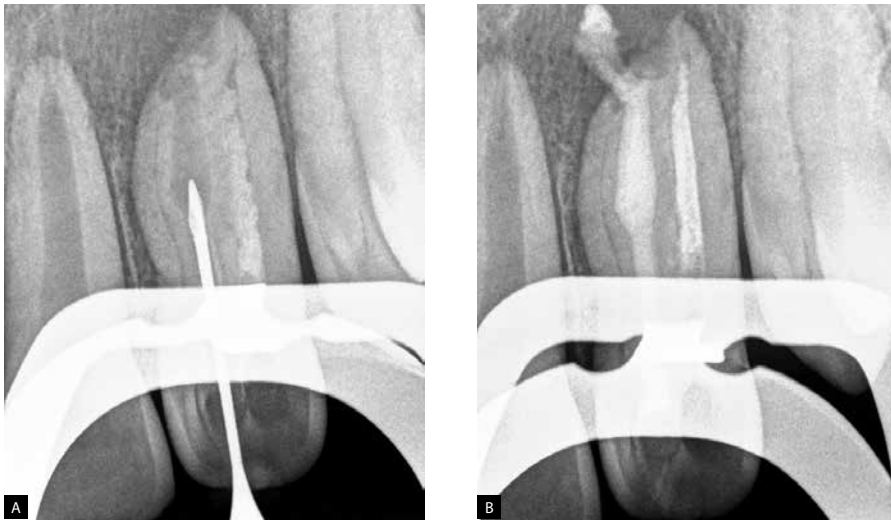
A) Periapical radiograph for teaching purposes: Gattes-Gliden bur inside dens invaginatus canal B) Intracanal medicament: $\text{Ca}(\text{OH})_2$ in dens invaginatus canal.
